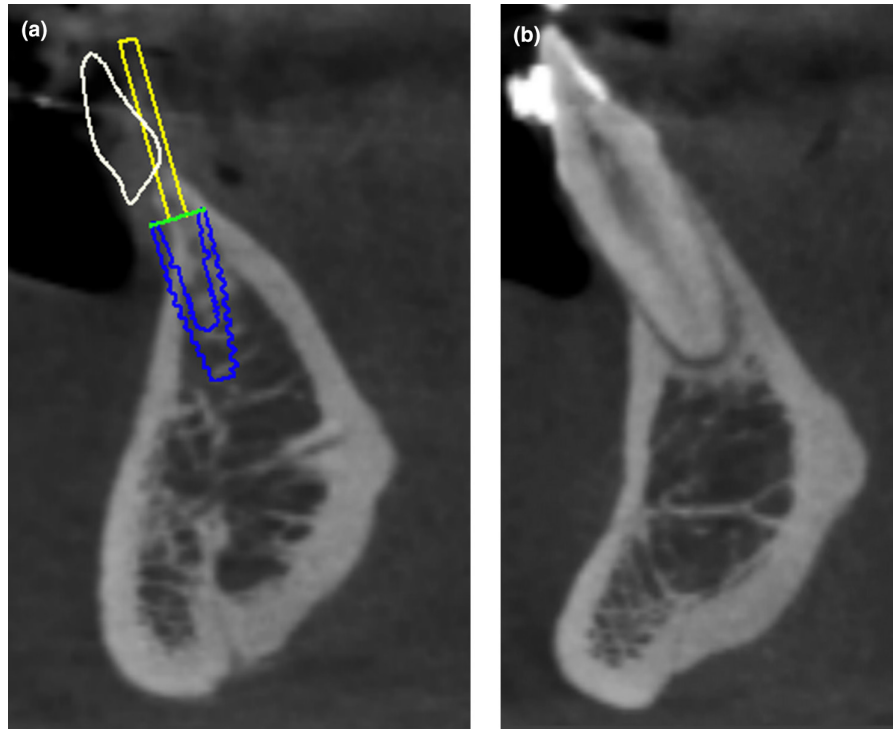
CBCT images of a mandibular lateral incisor (a) and central incisor (b) of the same patient which depicts the thin bucco-lingual bone at the crest of the ridge in edentulous sites and facial bone which appears absent around a mandibular incisor. The cortical bone is very thick and shapes of the mandibular basal bone in both sites are distinctly different.
